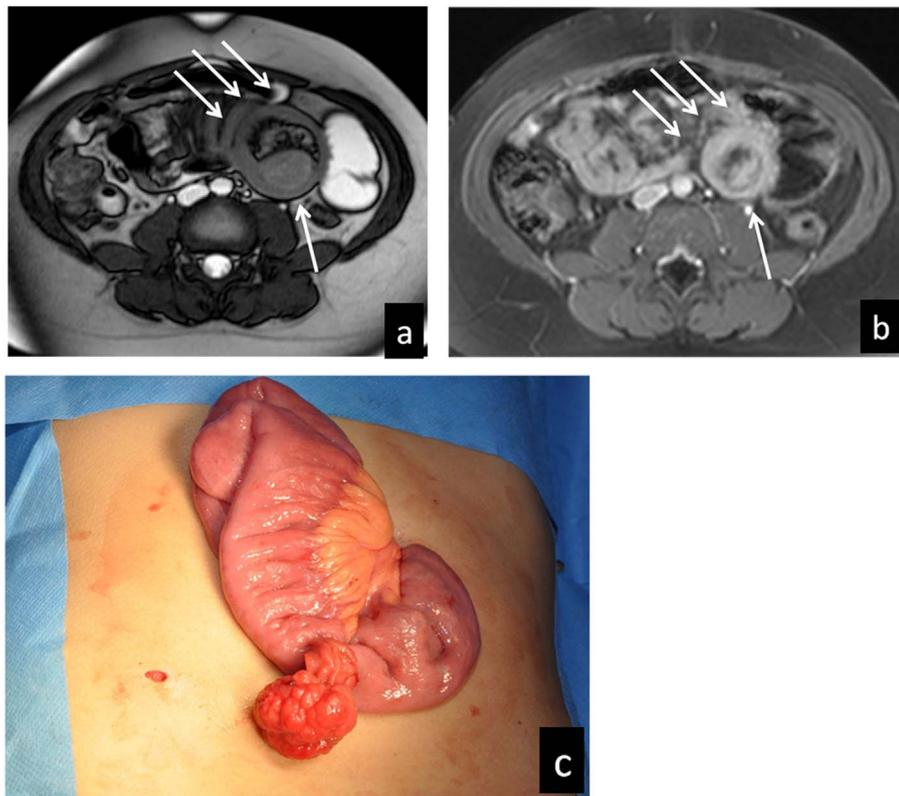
Polyp with intussusception in a 7-year-old child with anaemia and occult-type OGIB. Transverse TRUE FISP (a) and dynamic contrast-enhanced T1 fat saturation (b) MR images show a jejunal intussusception (arrows) due to a polyp (single arrow). The polyp was subsequently removed laparoscopically (c), instead of with balloon-assisted enteroscopy, because of the MRE result showing intussusception. Colour should be used for c
